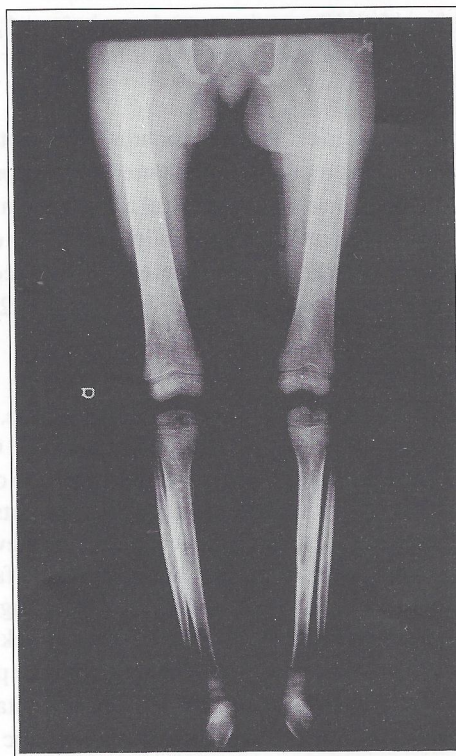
Antero posterior radiographs of both tibia (age 3 years) shows periosteal reaction in the form of cortical thickening and sclerosis
